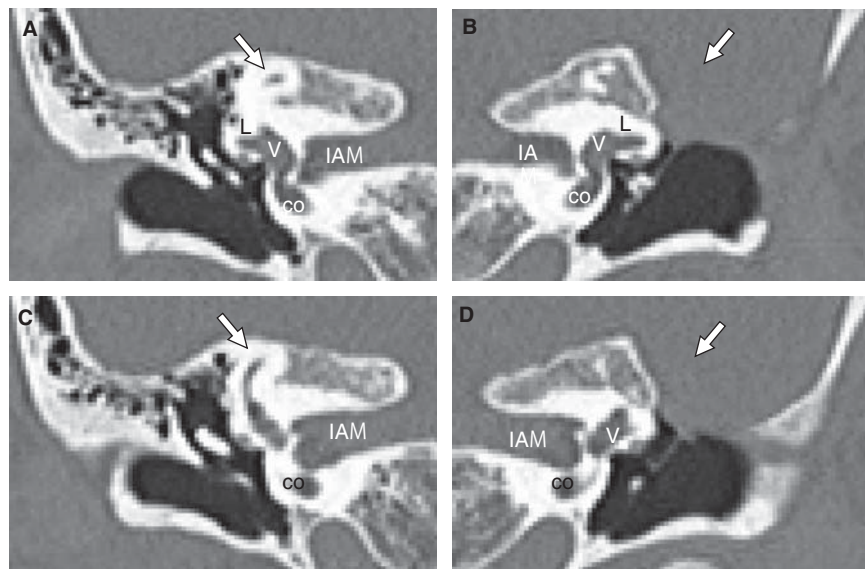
Case 2. CT after the surgery. (A, C) Right ear (normal). The superior semicircular canal (SSCC) is normally detectable. (B, D) Left ear (operated). SSCC is not detectable (arrow). co, cochlea; IAM, internal auditory meatus; L, lateral semicircular canal; V, vestibule.
